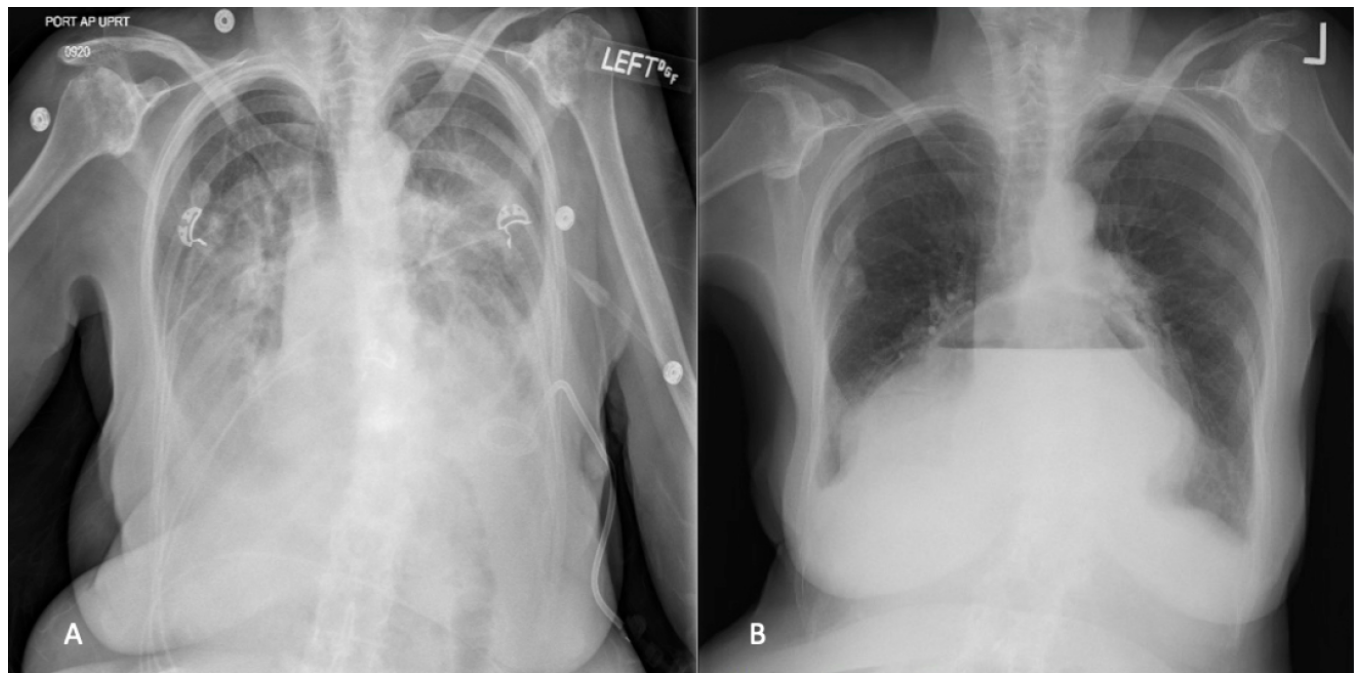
Patient #3 chest x-ray prior to discharge (A) and one-month after discharge following treatment with oral amoxicillin-clavulanate (B). A large hiatus hernia projects onto the mediastinum.
